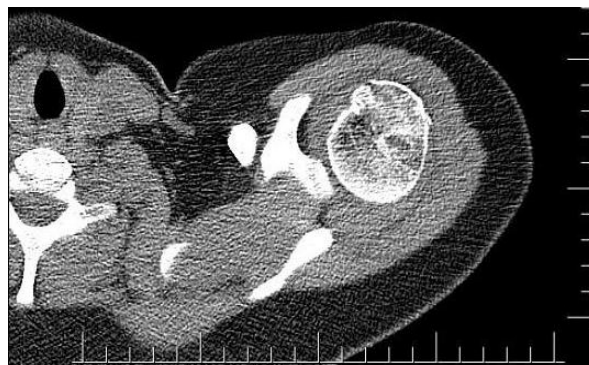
CT image of posterior dislocation.
